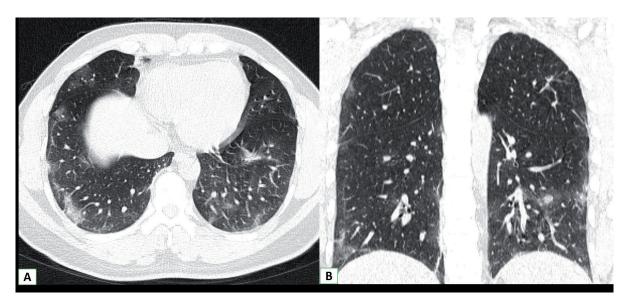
High resolution computed tomography of the thorax, axial (A) and coronal (B) images present multiple patchy areas of ground-glass opacities and consolidation in bilateral lungs predominately in the subpleural location. Findings are consistent with COVID-19 pneumonia
